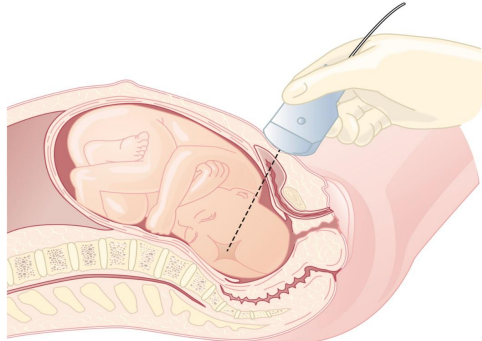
Obtaining a middle cerebral artery Doppler peak systolic velocity.
